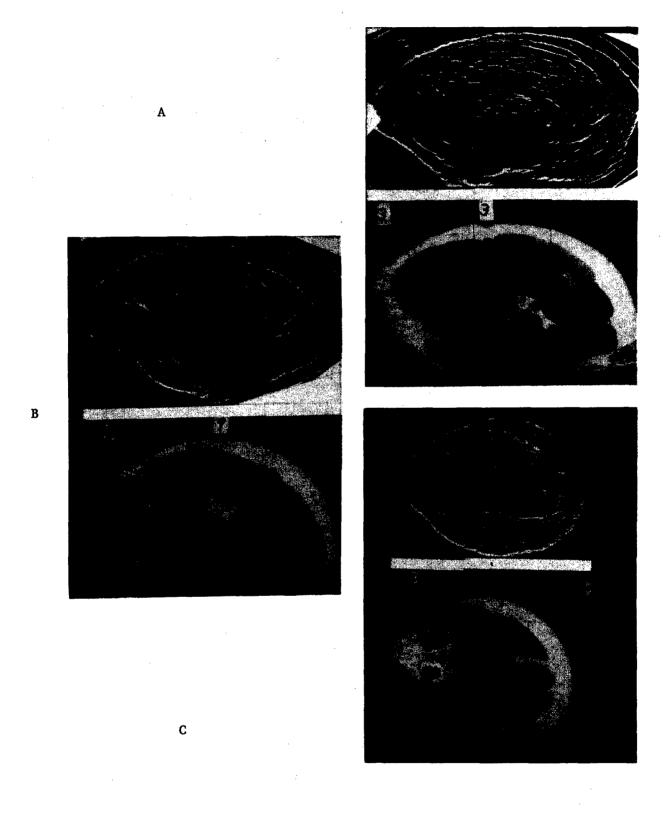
ULTRASONIC SCANS AND HAM CROSS SECTIONS AT SELECTED INTERVALS
